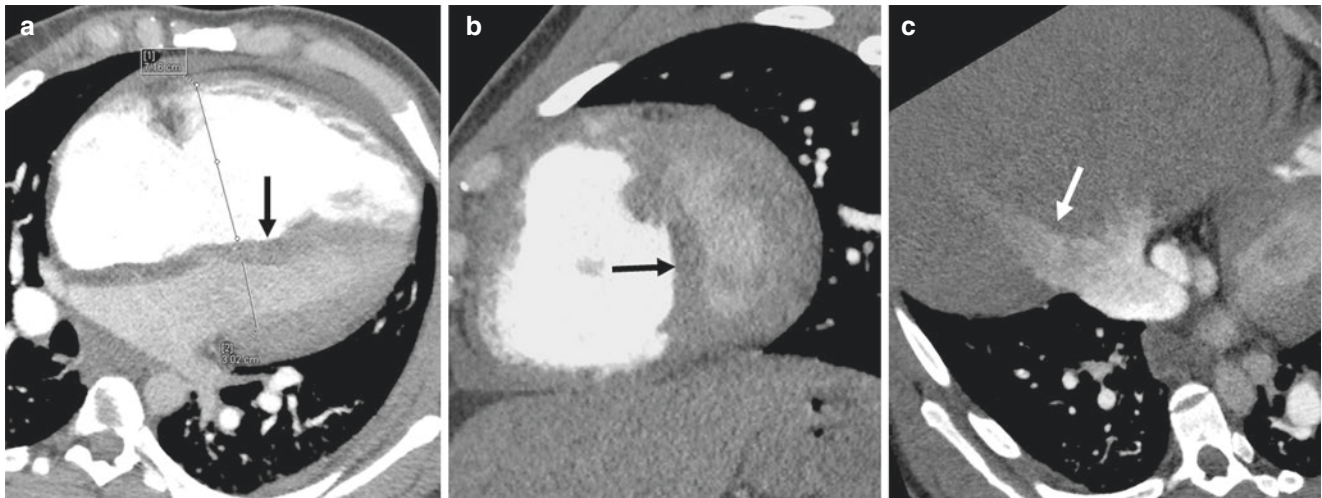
Features of RV dysfunction in CT. (a) Axial CT scan shows RV/LV diameter ratio of 2.4. (b) Short-axis reconstruction of CT shows dilated RV and bowing of the interventricular septum (arrow) toward the LV. (c) Reflux of contrast in hepatic veins and IVC (arrow)
